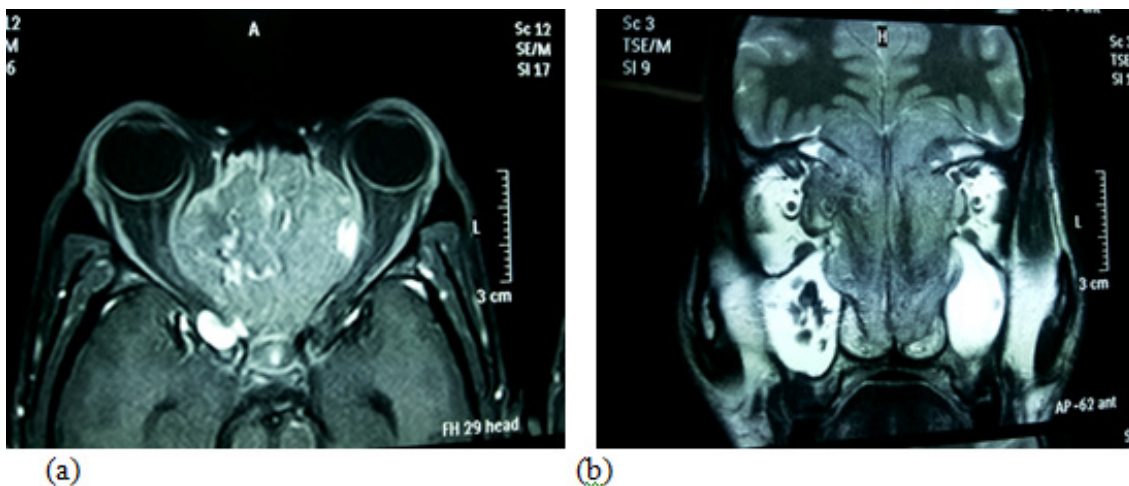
Gadolinium enhanced MRI showing a large JNA extending into both the orbits and also intracranial extension but extradural
